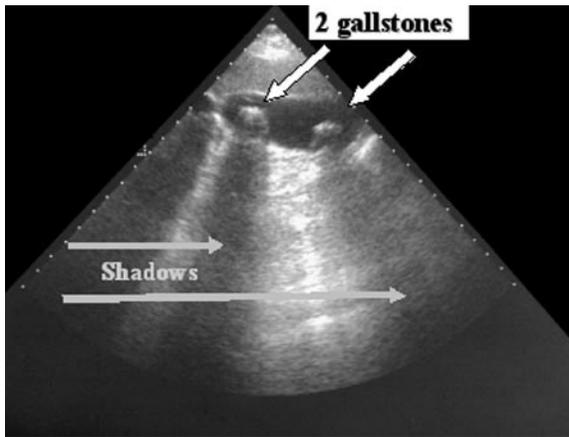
Abdominal ultrasound of two gallstones. In addition to each being echogenic, they each cast an acoustic shadow. Results in malabsorption. Stricture formation and recurrent cholangitis on occasion can lead to secondary biliary cirrhosis. Chronic duct obstruction and injury may lead to cholangiocarcinoma.
